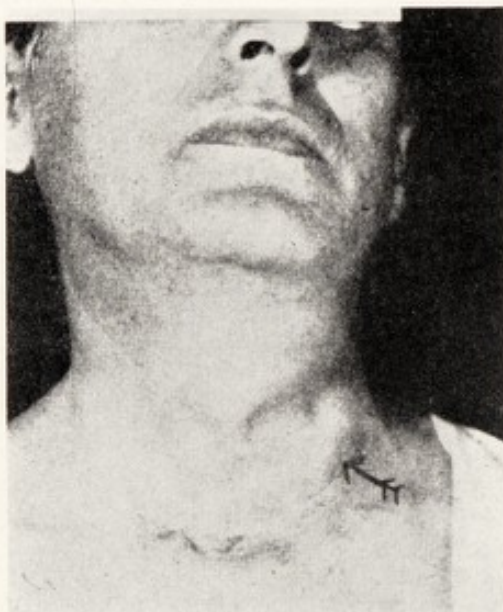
Malignant adenoma. Patient, forty-six years of age, who had had a tumor removed from the thyroid sixteen years before this picture was taken. There had been six recurrences in these sixteen years and seven courses of x-ray therapy had been administered; the general condition of the patient was satisfactory. (Arrow indicates recurrent nodule.)
